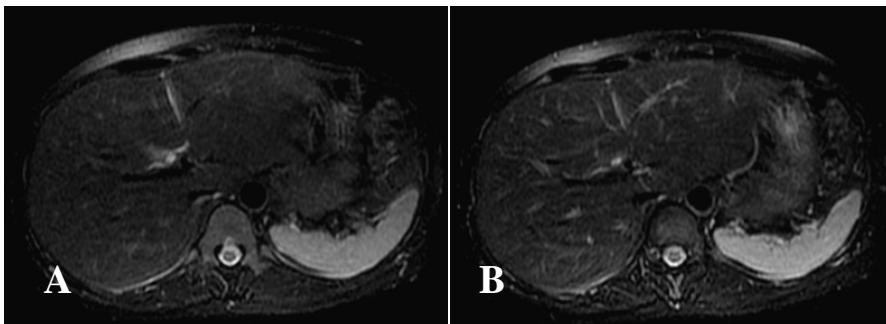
50-year-old woman. A and B, Breath-hold T2-weighted FSE images acquired before (A) and 4 minutes after (B) Gd-EOB-DTPA administration. B was rated as having same signal intensity of the liver parenchyma in comparison with A. B was rated as having higher signal intensity of the hepatic vessel in comparison with A.
